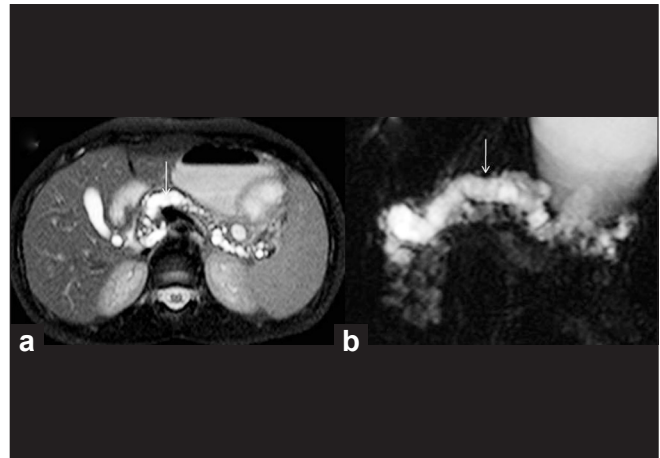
Chronic pancreatitis. Axial fat suppression T2-weighted MR image (a) and MRCP (b) shows atrophic pancreas with gross dilatation of main pancreatic duct and side branches (thin white arrow)
